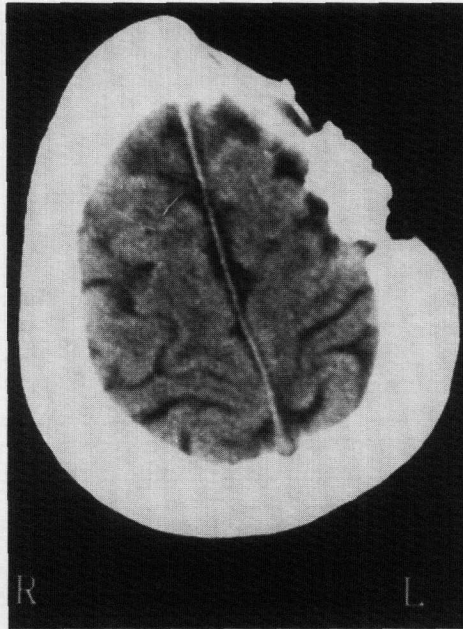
Antemortem CT of the parietal bones 3.0 cm below the vertex. (Note large defect on the left parietal.)
